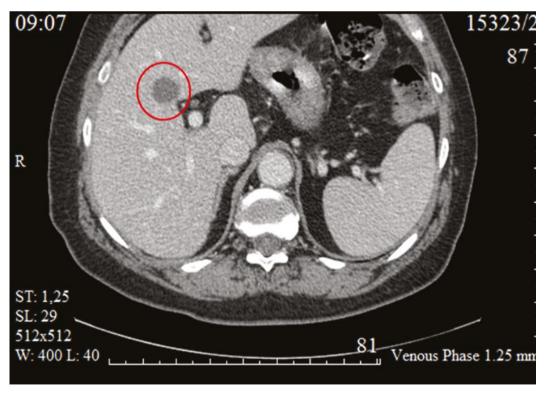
MRI of the abdominal cavity from 01.2023. Liver parenchyma structure with signs of cirrhosis. In S8/S5, a tumor node of HCC measuring 2.9×2.4 cm is determined. In other parts of the liver — without obvious tumor formations. The portal vein is dilated to 1.9 cm, without signs of thrombosis. Varicose veins of the esophagus. The spleen is enlarged to 18 cm.
